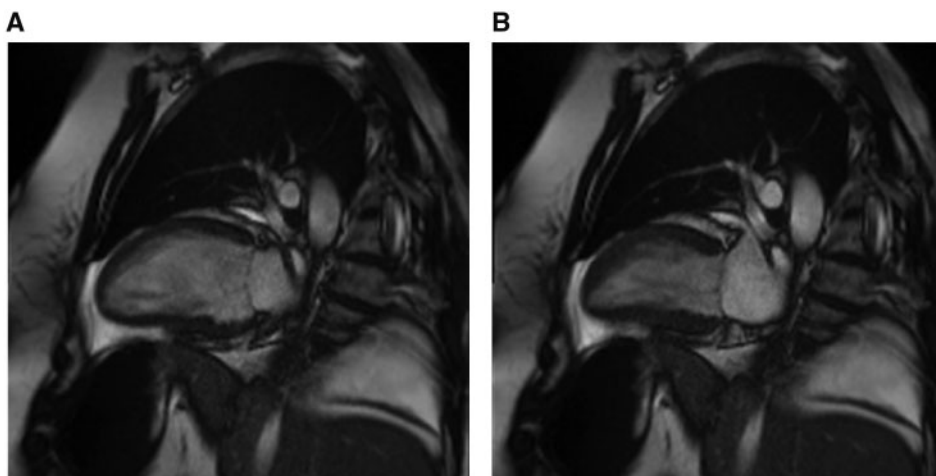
Cardiac magnetic resonance imaging on Day 4 of admission—two-chamber axis views in end-diastole (A) and end-systole (B) showing good basal contraction and hypokinetic mid-apical left ventricle.
